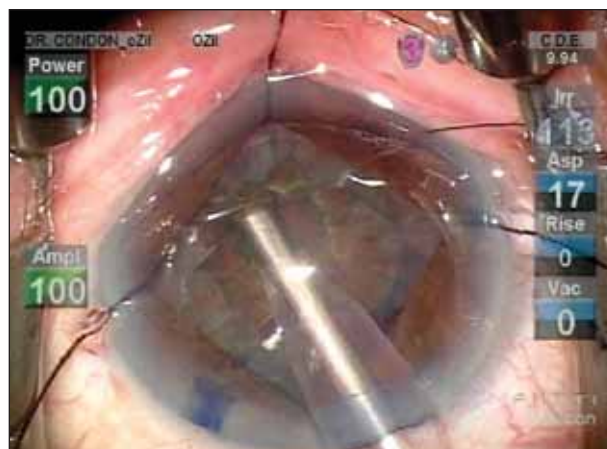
The author phacoemulsifies the cataract inside the capsular bag using a combination of torsional and longitudinal ultrasound.
